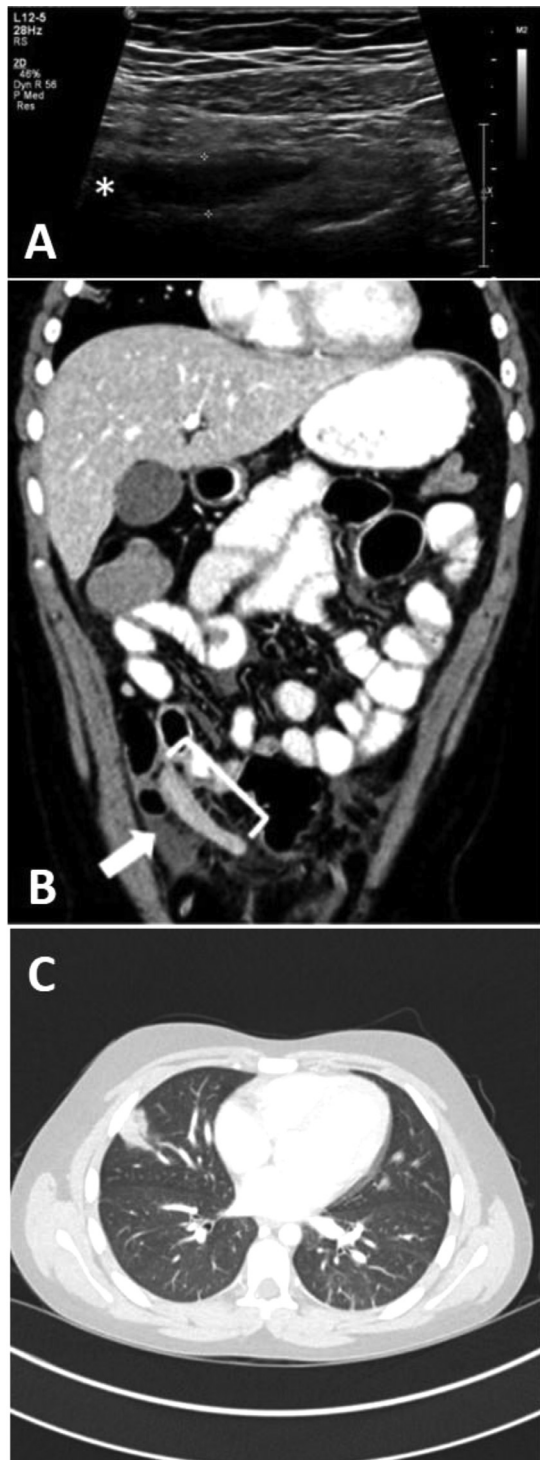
Patient 1-12-year-old male: (A) right lower quadrant United States performed with a linear high-resolution probe demonstrating a dilated 11 mm noncompressible appendix, more prominent at the base (*). (B) Coronal contrast enhanced CT with oral contrast demonstrating a dilated appendix (bracket) and fluid in the right lower quadrant (arrow). (C) Axial contrast-enhanced CT displaying nonspecific wedge-shaped region of consolidation with minimal ground glass present on admission imaging; however, the patient had no respiratory symptoms.
